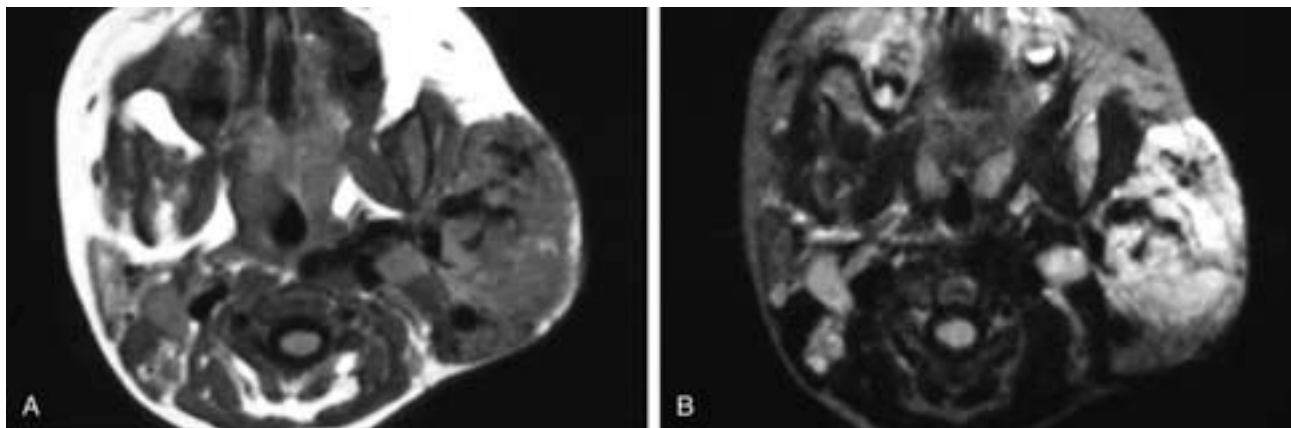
Axial T1-weighted (A) and T2-weighted (B) MR images show a large soft tissue mass replacing the ventral portion of the left parotid gland. Within the mass there are serpiginous vascular flow voids. This child had an hemangioma.
